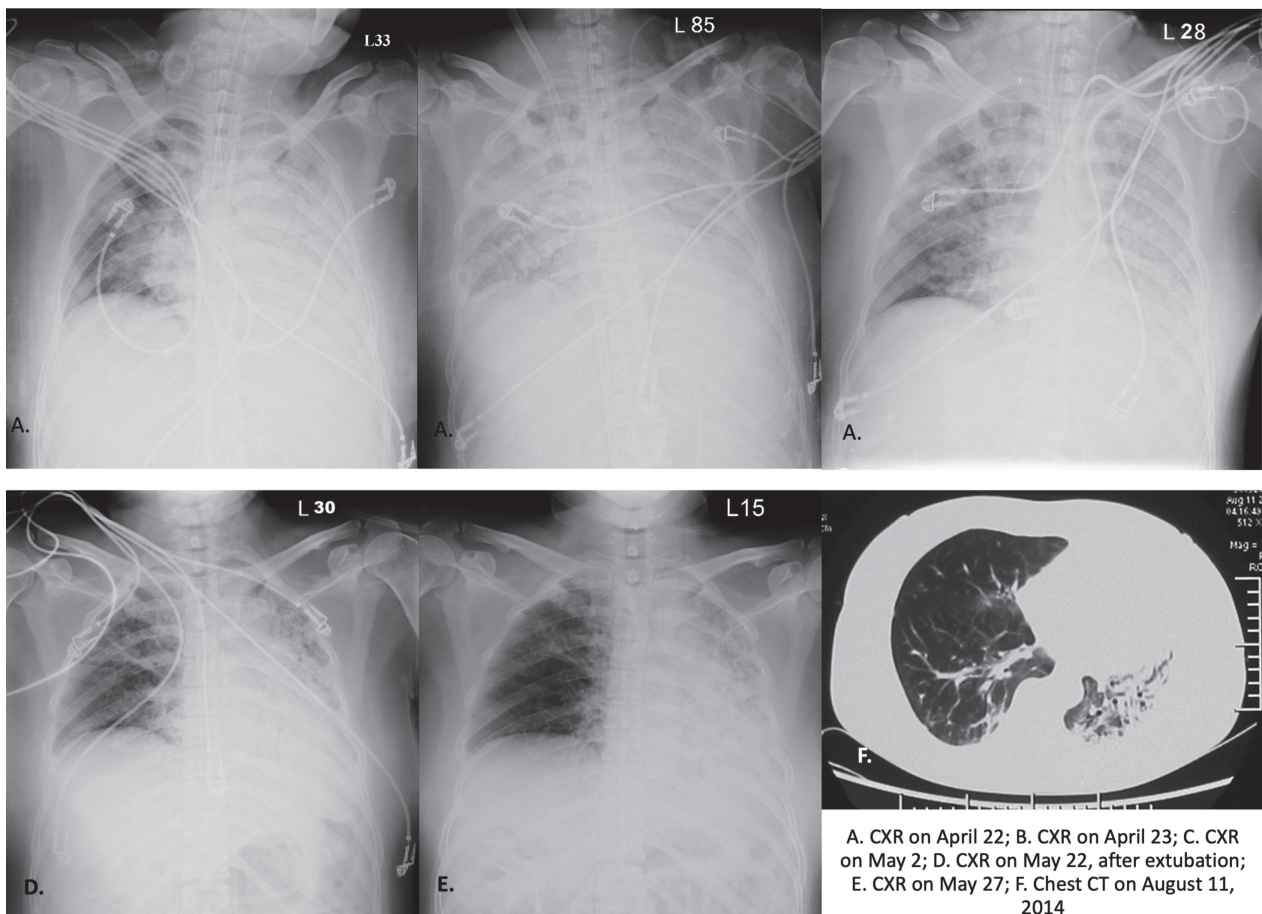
A. Chest X-ray (CXR) on April 22, the day after intubation; B. CXR on April 23, the day ECMO began; C. CXR on May 2, the day ECMO was removed; D. CXR on May 22, after removal of the endotracheal tube; E. CXR on May 27, the day before discharge; F. Chest CT on August 11, 2014.
